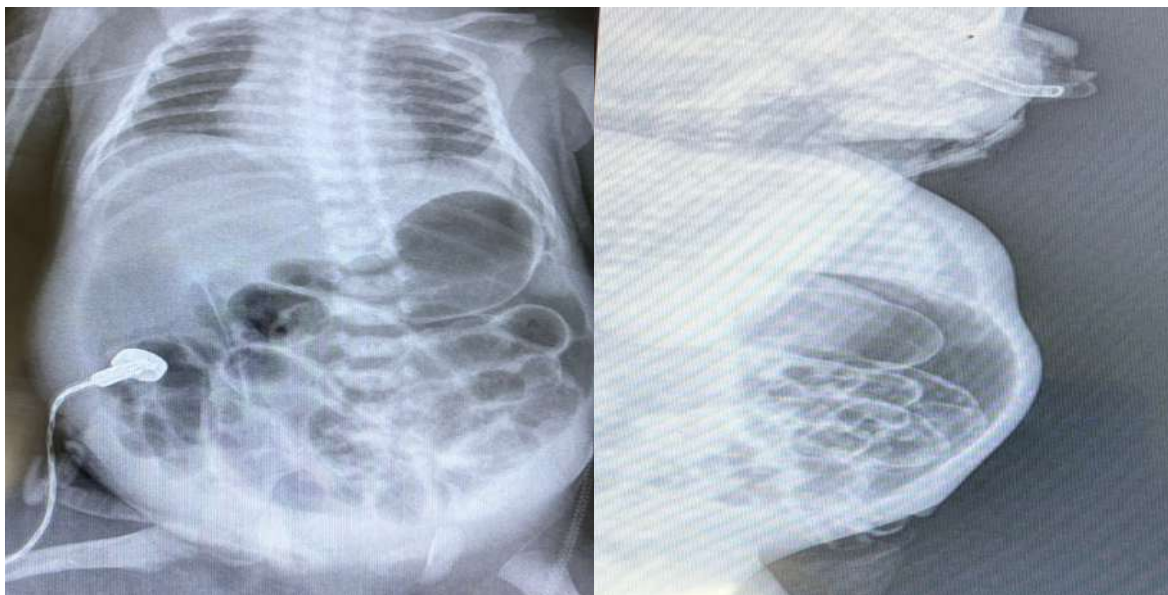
Erect X-ray abdomen showing neonatal intestinal obstruction with suspected Hirschsprung's disease.
